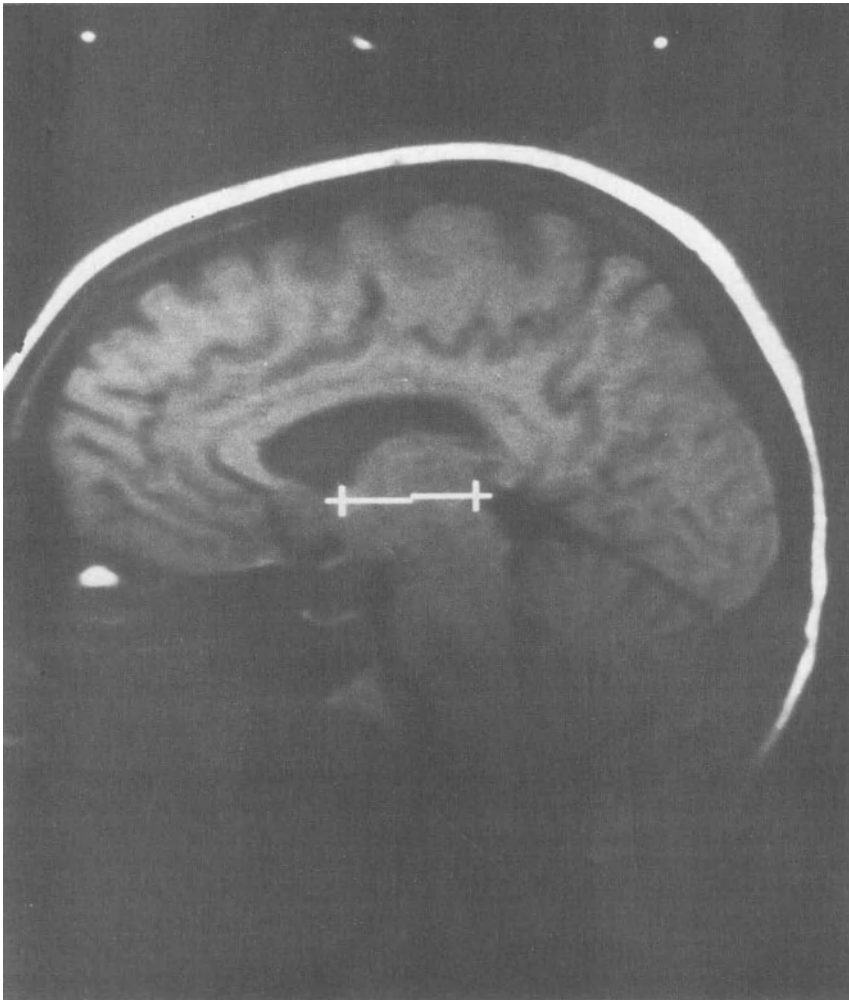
Sagittal stereotactic MRI anatomic (T_1 -weighted) image, demonstrating the intercommissural line prior to thalamotomy.
